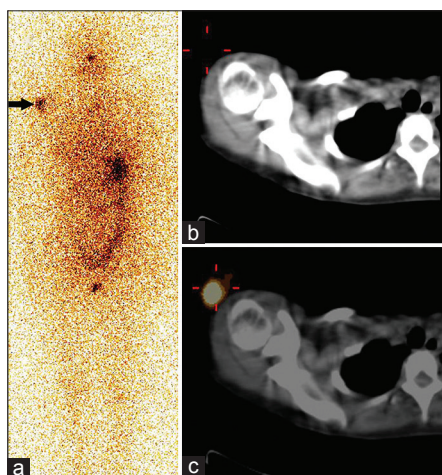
Pretherapy I-131 planar whole-body anterior view image (a) of a 26-year-old female patient with papillary thyroid cancer demonstrated intense tracer uptake in the right arm region (arrow) with physiological tracer uptake in the stomach, bowel and bladder. Transaxial CT (b) and corresponding transaxial fused single photon emission computed tomography/computed tomography images (c) of right arm showing tracer activity outside the body confirming this as surface contamination
